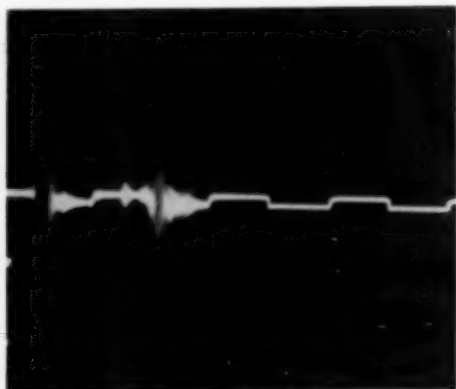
(Mundt and Hughes). Ultrasonic tracing in which the rubber membrane of the searching unit was placed directly on the cornea. Lower photographic magnification than in previous pictures. This eye contained a malignant melanoma of the choroid.
